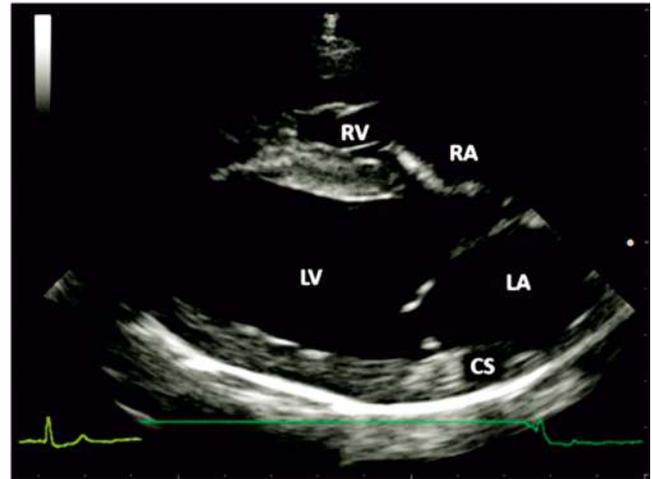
Right parasternal four-chamber view underlying the coronary sinus (RV-right ventricle, RA-right atrium, LV-left ventricle, LA-left atrium, IVS-interventricular septum, CS-coronary sinus)
